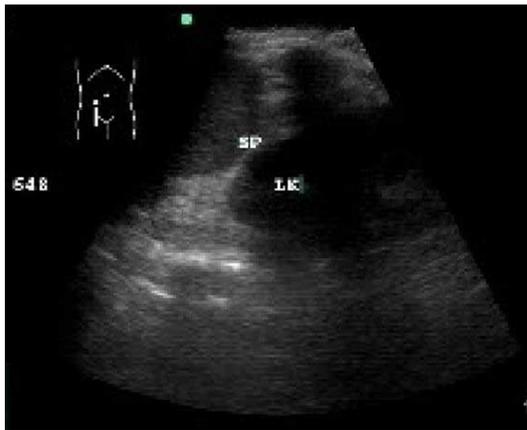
Moderate ascites on B ultrasound after treatment with IL-11.
